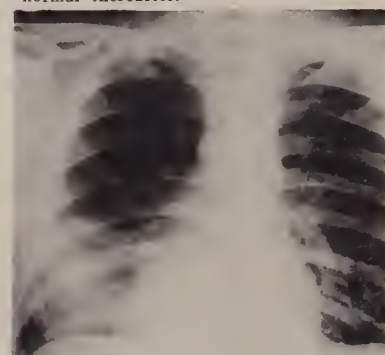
Case F. V. Radiograph of chest on admission.
